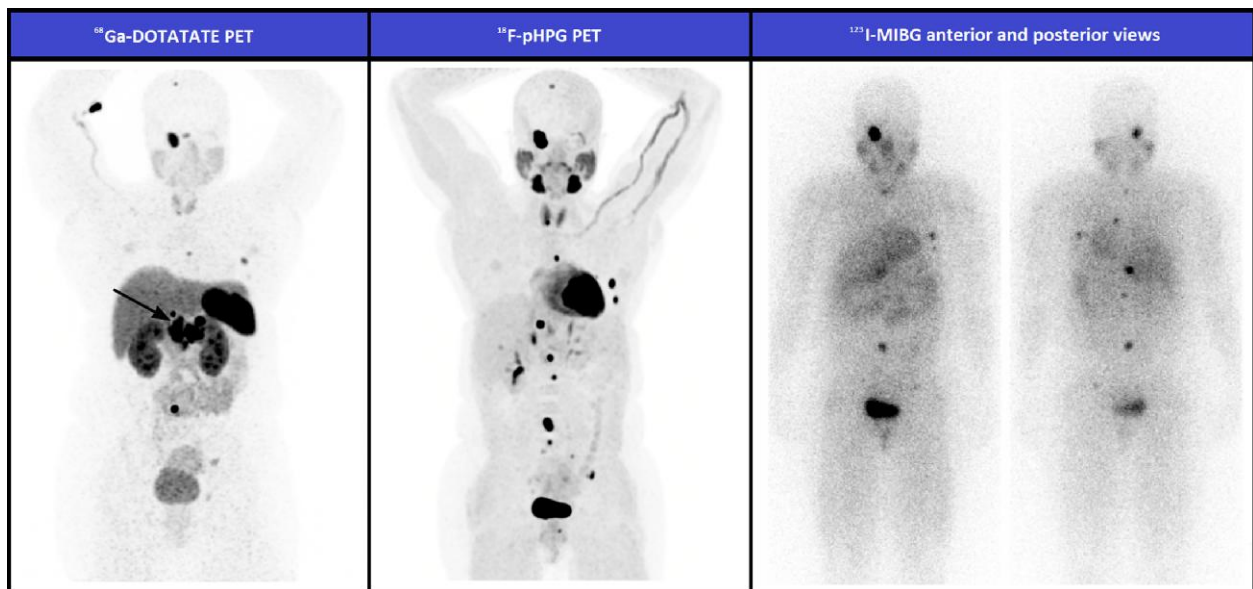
A 43-year-old woman (patient 2) with metastatic paraganglioma. Comparison between left: [^{68}Ga]DOTATATE PET, middle: 3- ^{18}F]pHPG PET, and right: [^{123}I]mIBG scan. She initially presented with preeclampsia and was found to have a large abdominal paraganglioma. Clinically she had worsening hypertension, palpitations, lightheadedness, and shortness of breath. Computed tomography scan revealed a mass posterior to the pancreas, between the aorta and vena cava, and there was metastatic osseous disease in the right orbital ridge and in the thoracic and lumbar spine (standardized uptake value [SUV_{max}] of 38.7). She underwent exploratory celiotomy and excision of retropancreatic paraganglioma (arrow), seen on the preoperative [^{68}Ga]DOTATATE PET, which has been surgically resected on the postoperative 3- ^{18}F]pHPG PET. 3- ^{18}F]pHPG PET and [^{68}Ga]DOTATATE PET had similar detection of osseous metastases, though 3- ^{18}F]pHPG PET detected a liver metastases (SUV_{max} of 4.1) not evident on [^{68}Ga]DOTATATE PET, likely due to lower background hepatic activity. 3- ^{18}F]pHPG PET detected more bone metastases than the comparison postoperative [^{123}I]mIBG scan.
